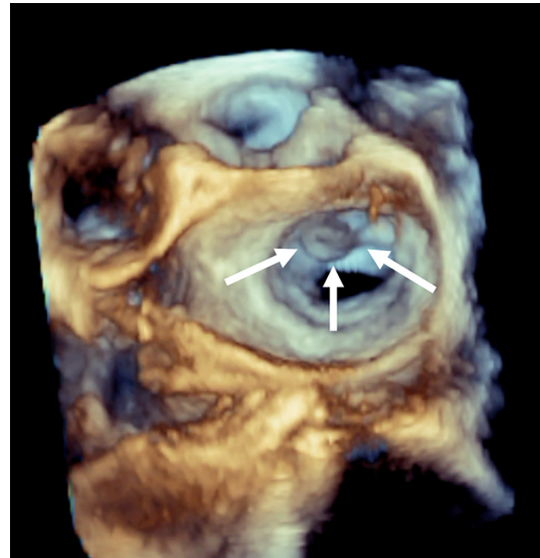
Three-dimensional transesophageal echocardiography mitral examination showing an aneurysm of anterior mitral valve middle scallop. White arrows indicating aneurysm of anterior mitral leaflet.
